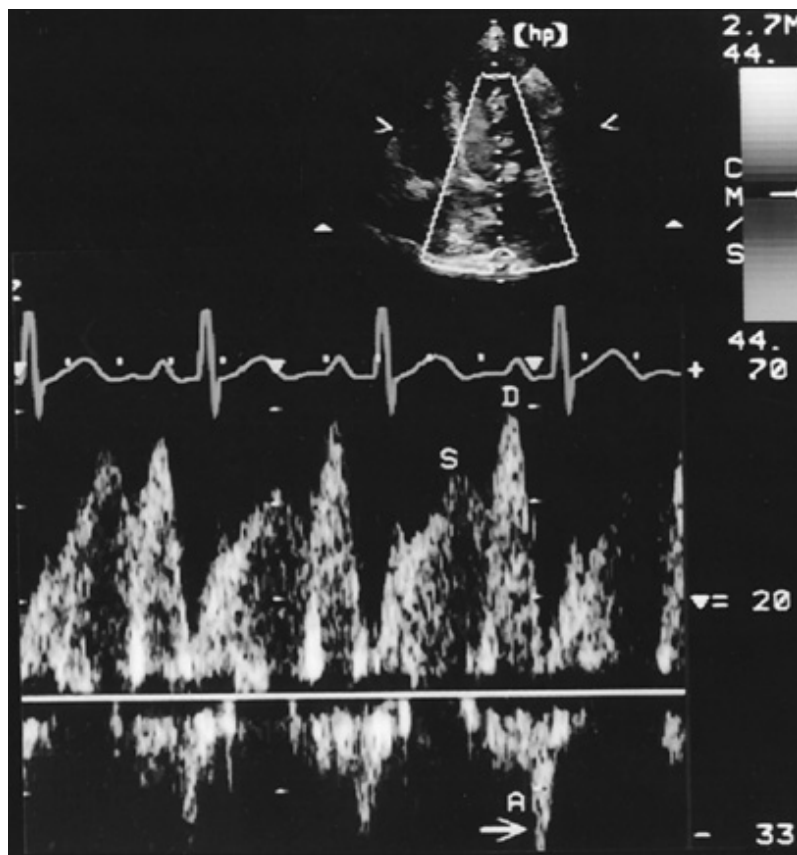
Pulsed-wave Doppler tracing from the right upper pulmonary vein (recorded from the apical transducer position). Flow toward the heart is biphasic, with peaks in systole (S) and diastole (D). A small amount of reversed flow is seen during atrial contraction (A).
